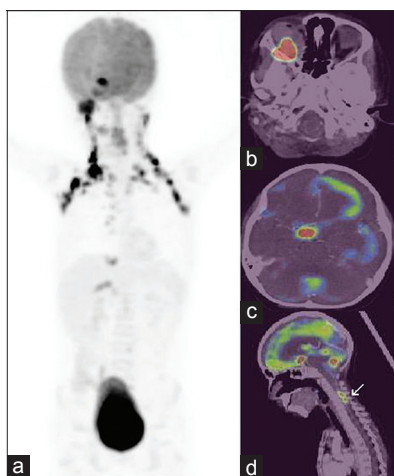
Whole body contrast enhanced fluorodeoxyglucose-positron emission tomography/computed tomography (FDG PET/CT) maximum intensity projection image (a) Axial fused-PET/CT showed intense uptake in the soft tissue lesion in the right orbit (b) suprasellar mass lesion and (c) sagittal fused-PET/CT showing drop metastasis in cervical spinal canal level (d, arrows). Also, physiological brown fat uptake noted in bilateral cervical, supraclavicular, and paravertebral locations
